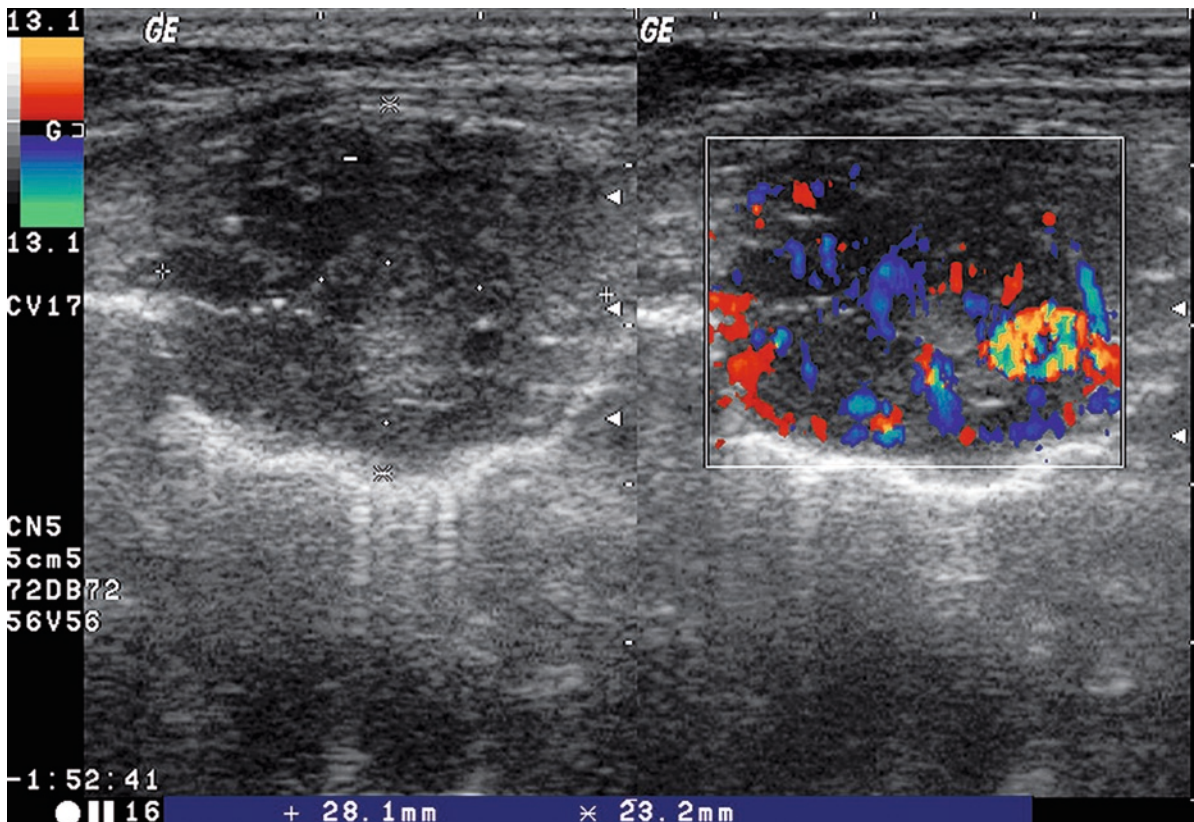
A highly malignant non-Hodgkin's lymphoma invading the ribs, with pathological neoformation of vessels on color-Doppler sonography. The diagnosis was established by sonography-guided aspiration
